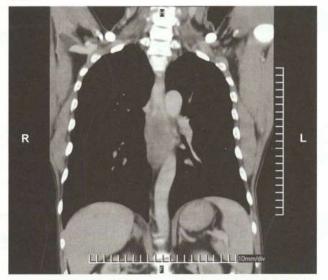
Contrast CT showing a large midoesophageal growth
